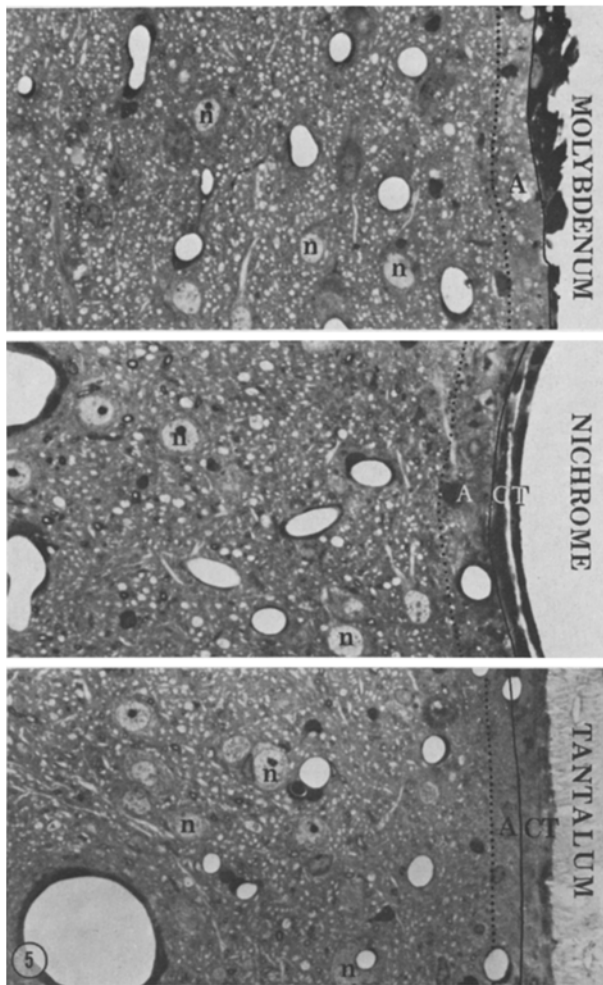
The brain-implant boundary of reactive metal implants is marked by astrocytosis (*A*) and connective tissue (*CT*). Cerebral cortex with neurons (*n*) surrounds the zone of astrocytosis. Molybdenum (227 days), nichrome (197 days), and tantalum (196 days). $\times 400$
